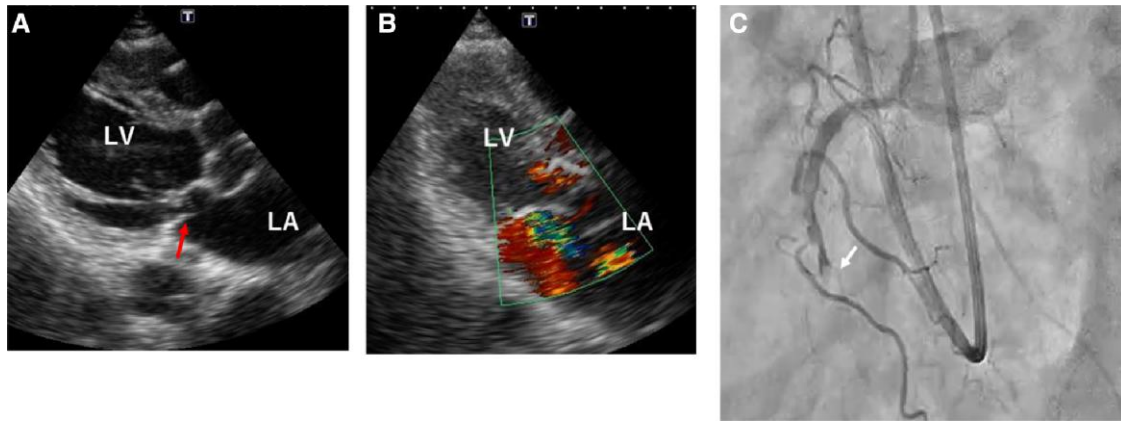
Transthoracic echocardiography and coronary angiography. (A) Parasternal long-axis view reveals the flail posterior mitral valve leaflet at systolic phase (arrow). (B) Color Doppler image showed severe mitral regurgitation (MR). (C) Left anterior oblique straight view of the right coronary artery shows complete occlusion (arrow). LA, left atrium; LV, left ventricular.
